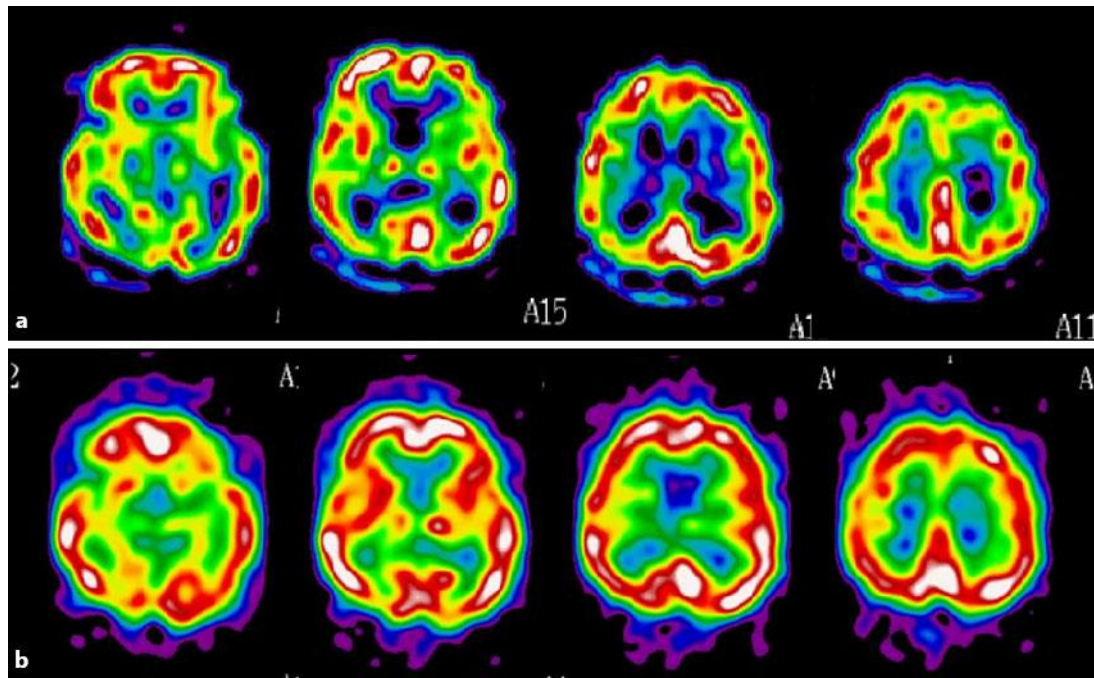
SPECT 31 days (a) and 187 days (b) after stroke onset. SPECT 31 days after stroke onset revealed reduced perfusion in the brain stem, bilateral basal ganglia, and frontal and parietal lobes in the left hemisphere. SPECT 187 days after stroke onset showed an improvement in cerebral blood flow in the posterior fossa and the cerebral hemispheres in the frontal and temporal lobes bilaterally.
